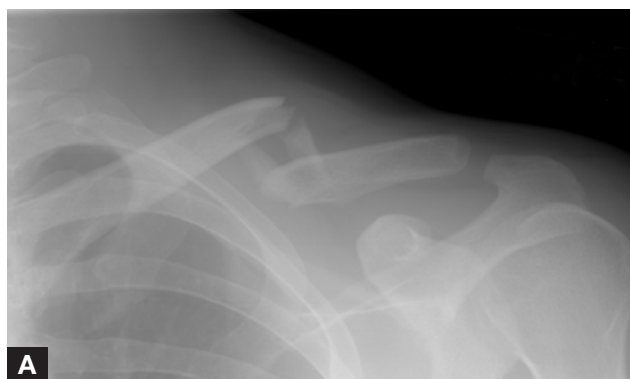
Nonunion: (A) injury radiograph, (B) intraoperative image, (C) 5 months after injury.
